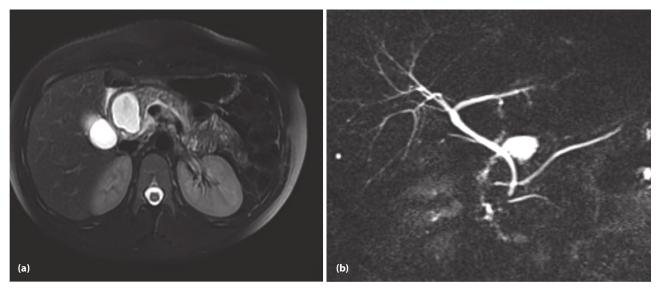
Abdominal magnetic resonance imaging (MRI) (a) and angiography (b) revealed gastroduodenal artery aneurysm.
